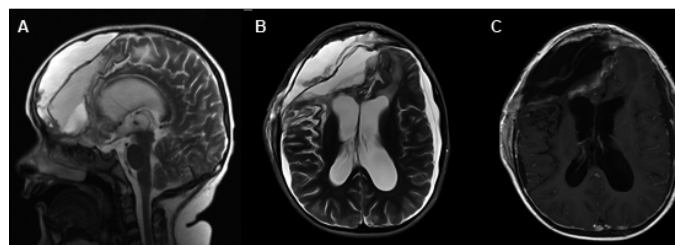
Follow-up postoperative MRI: (A) T2 sagittal; (B) T2 axial; (C) T1W gadolinium -enhanced axial.
